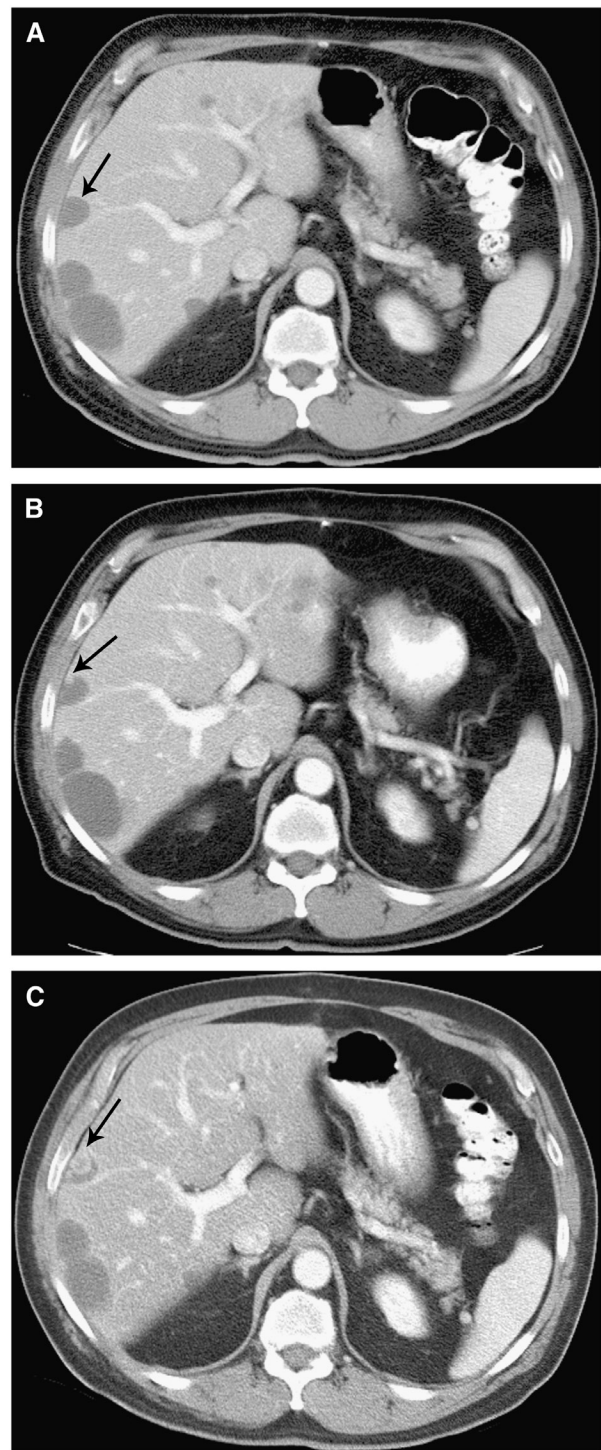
Intratumoral recurrence after imatinib in a 72-year-old man with a primary gastrointestinal stromal tumor in the duodenum. (A) An enhanced CT image obtained 12 months after treatment showed multiple, treated, hypodense metastasis in both lobes of the liver (arrow). (B, C) On follow-up CTs, a continuously increasing intratumoral nodule (arrow) was noted at 17 months (B) and 22 months (C) after treatment. Courtesy of Haesun Choi, MD, The University of Texas M. D. Anderson Cancer Center.
